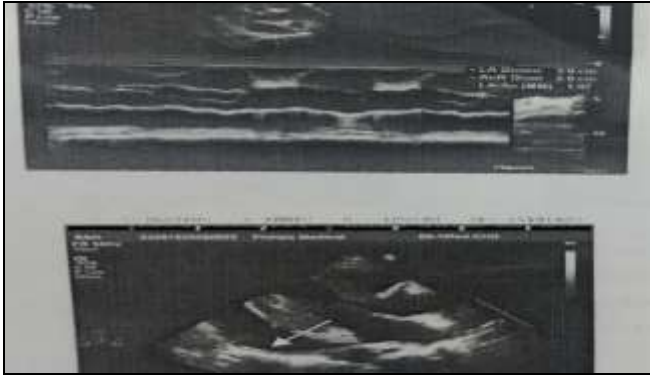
Transthoracic and M Mode-2D Echocardiography Showing Massive Pericardial Effusion
